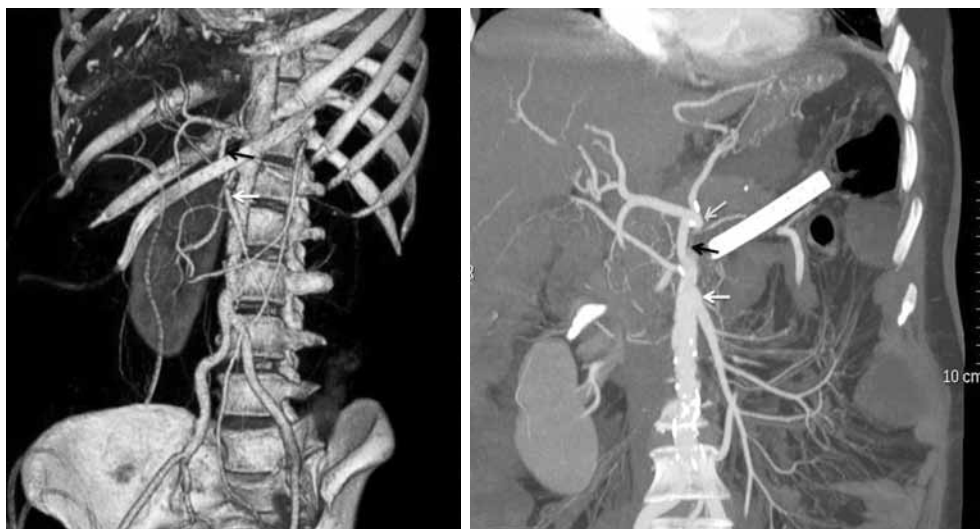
The postoperative computed tomography angiography shows the patent splenic artery-to-superior mesenteric artery bypass. The white arrow indicates the superior mesenteric artery, the black arrow indicates the splenic artery, and the gray arrow indicates the celiac artery. White arrow: Superior mesenteric artery; Black arrow: Splenic artery; Gray arrow: Celiac artery.
